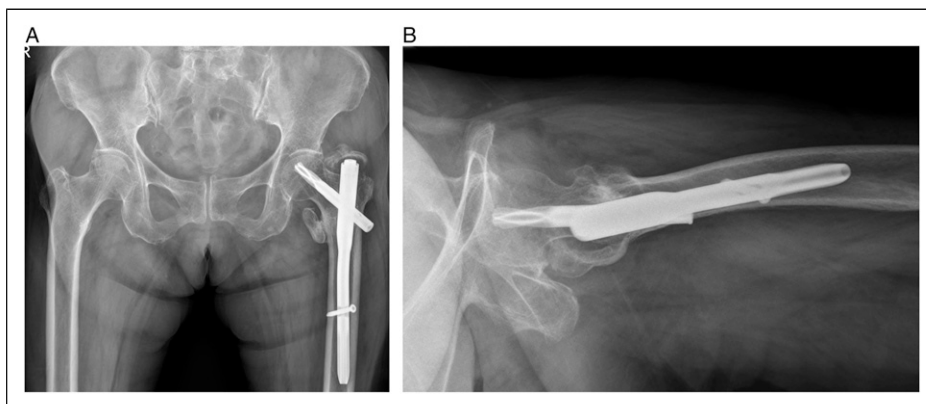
(A and B) 16 months after operation, follow-up X-ray showed well union of fracture site with consolidation and greater trochanter tip fragmentation.
